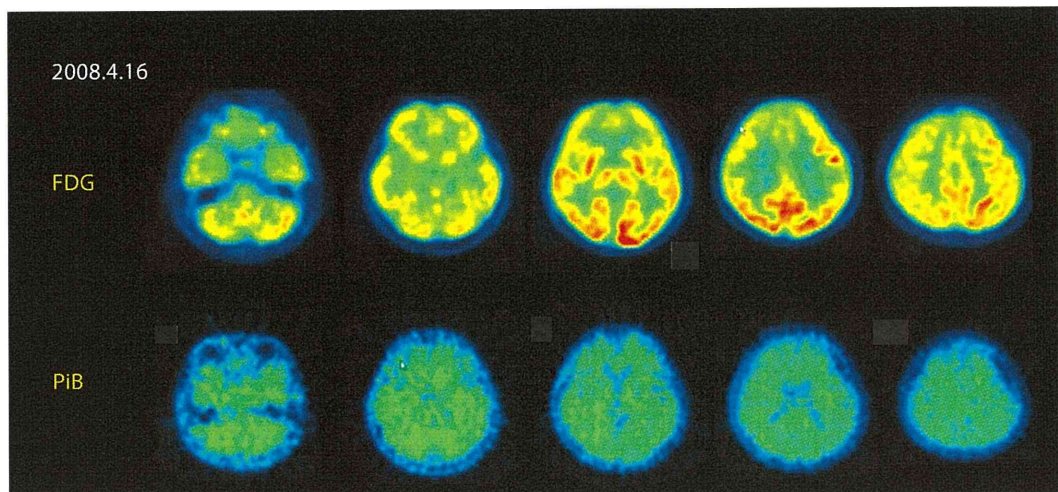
FDG- and PiB-PET images of patient 2. PiB-PET images show no accumulation of amyloid in her brain, similar to that seen in patient 1.
